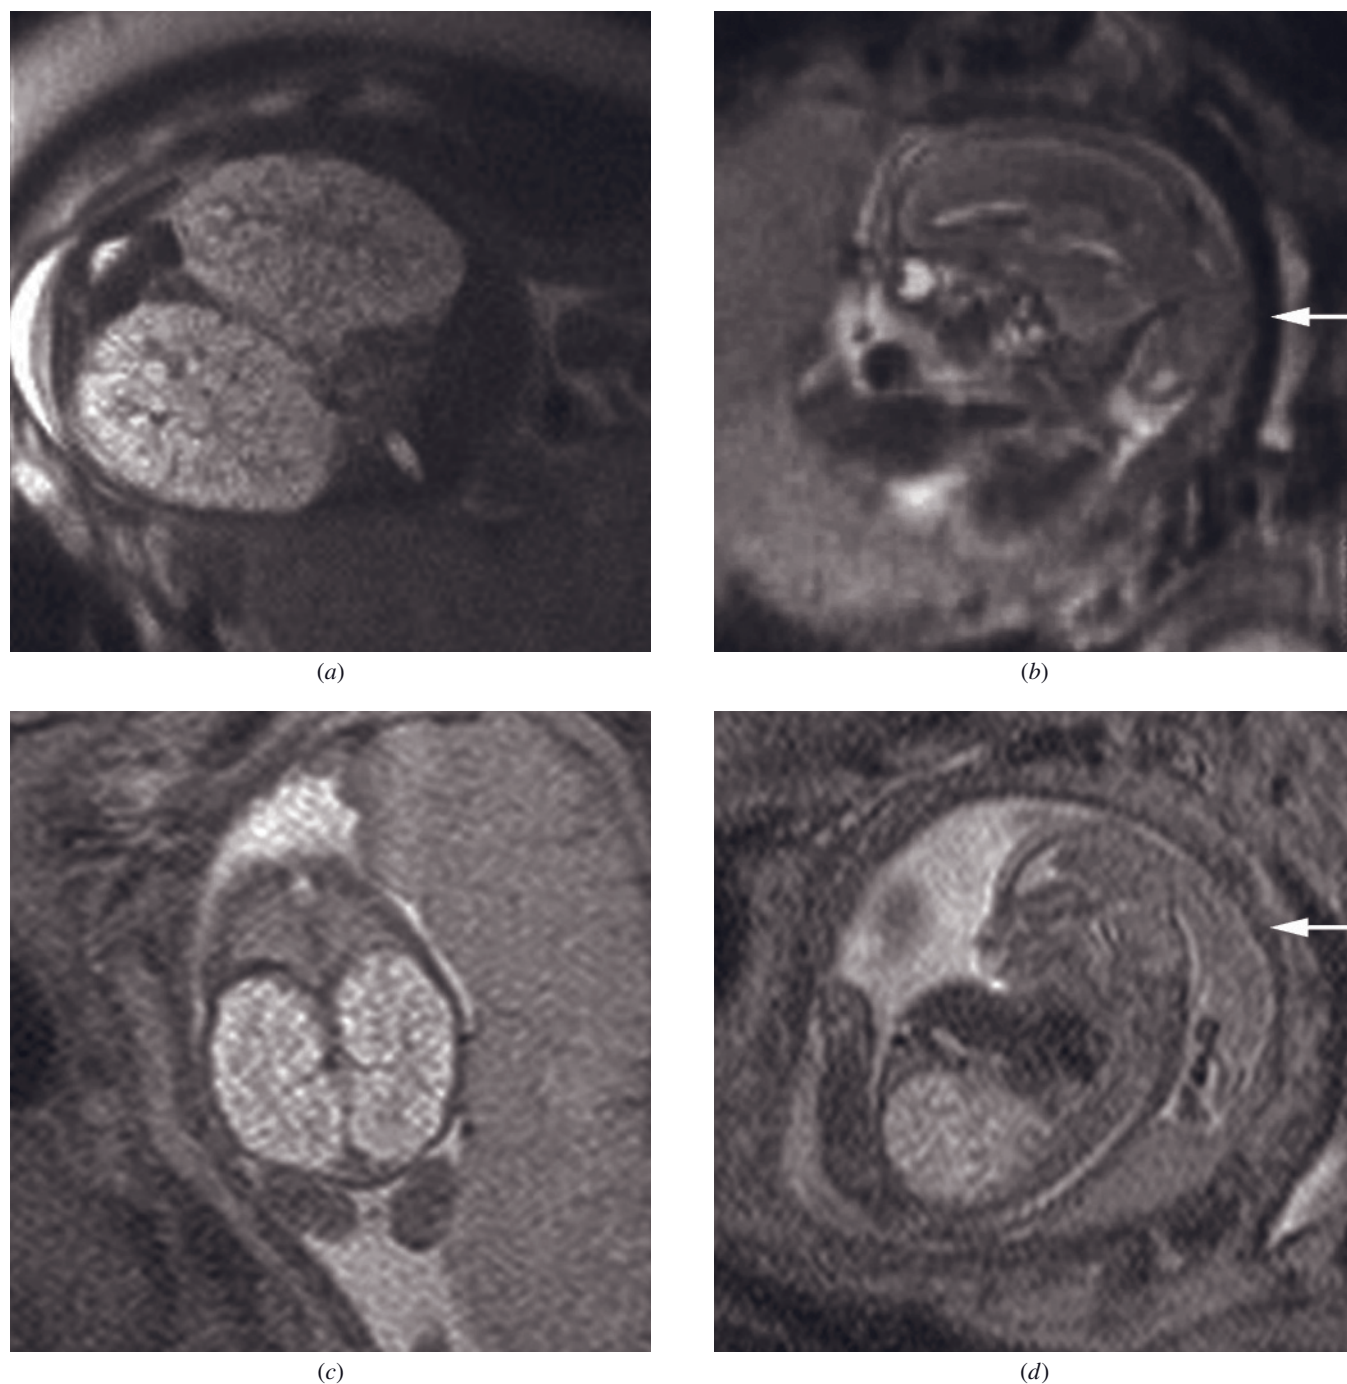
Meckel-Gruber syndrome. Coronal T2-weighted SS-ETSE image of the kidneys in a 20-week fetus (*a*) demonstrates enlarged, hyperintense kidneys bilaterally measuring 5.7 cm, with innumerable small cysts. Sagittal T2-weighted SS-ETSE image of the fetal head (*b*) demonstrates herniation of brain tissue posteriorly (arrow), consistent with an occipital encephalocele. Coronal T2-weighted SS-ETSE image of the kidneys in a different fetus at 17 weeks of gestation (*c*) also reveals polycystic kidneys with enlarged, hyperintense kidneys bilaterally containing innumerable small cysts. Sagittal T2-weighted SS-ETSE image of the fetal head (*d*) also demonstrates an occipital encephalocele (arrow).
